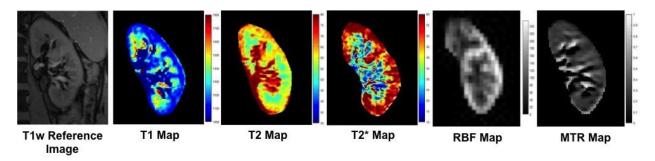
Example quantitative MRI maps in a healthy volunteer.
